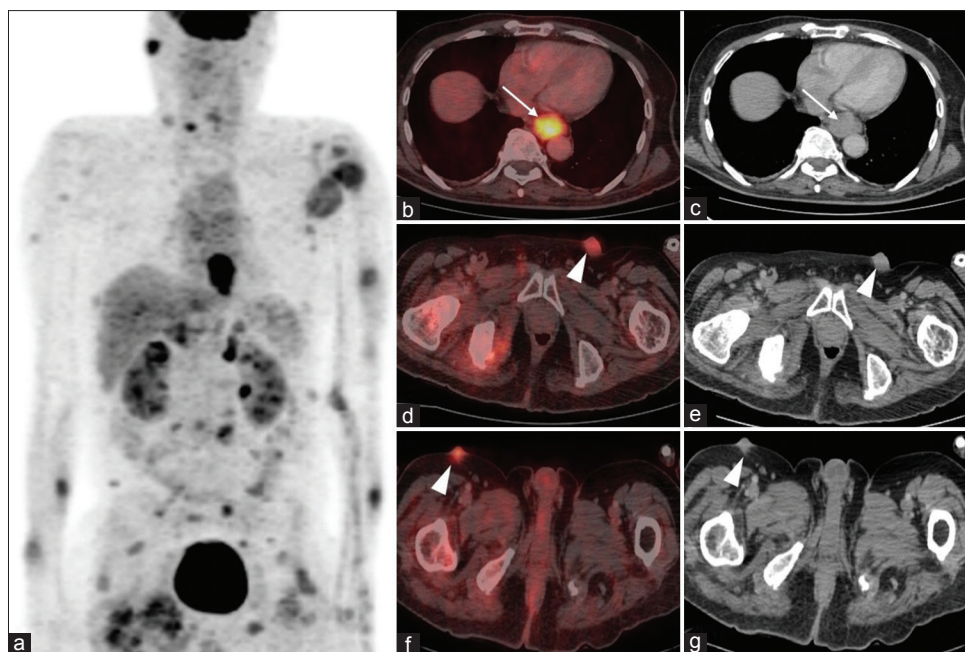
MIP image (a) showing multiple lesions of abnormal fluorodeoxyglucose uptake which on transaxial fused positron-emission tomography-computed tomography and computed tomography images (b and c) localized to asymmetrical mural thickening with the mass formation in the lower end of the esophagus (arrow). Additionally increased fluorodeoxyglucose uptake was also noted in multiple cutaneous lesions (arrow head; d-g) suggestive of metastatic disease
